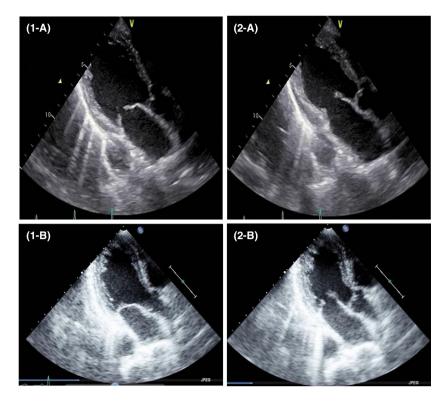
(1) Echocardiography performed on the 9th day of hospitalization just before starting steroid therapy. Diffuse hypokinetic and slight LV dilation can be seen. (1-A) Systolic phase and (1-B) diastolic phase. (2) Repeated echocardiography performed on the 51st day of hospitalization at approximately 4 weeks after steroid therapy. LV wall motion was normalized. (2-A) Systolic phase and (2-B) diastolic phase.
